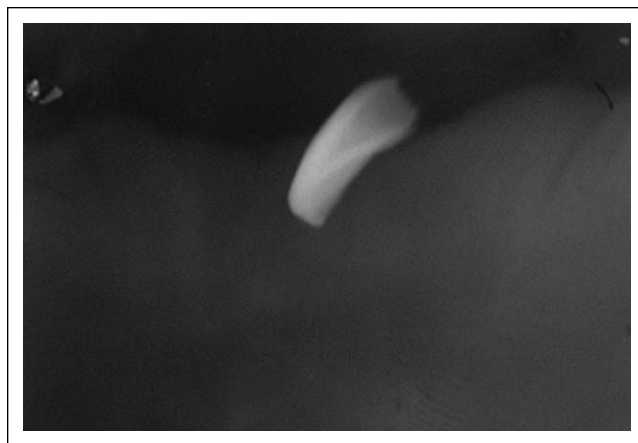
Soft-tissue roentgenogram showing presence of radio-opaque fragment
